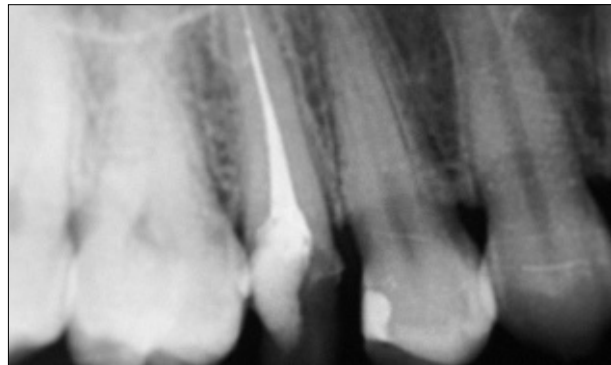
Periapical radiograph taken in January 2007.
